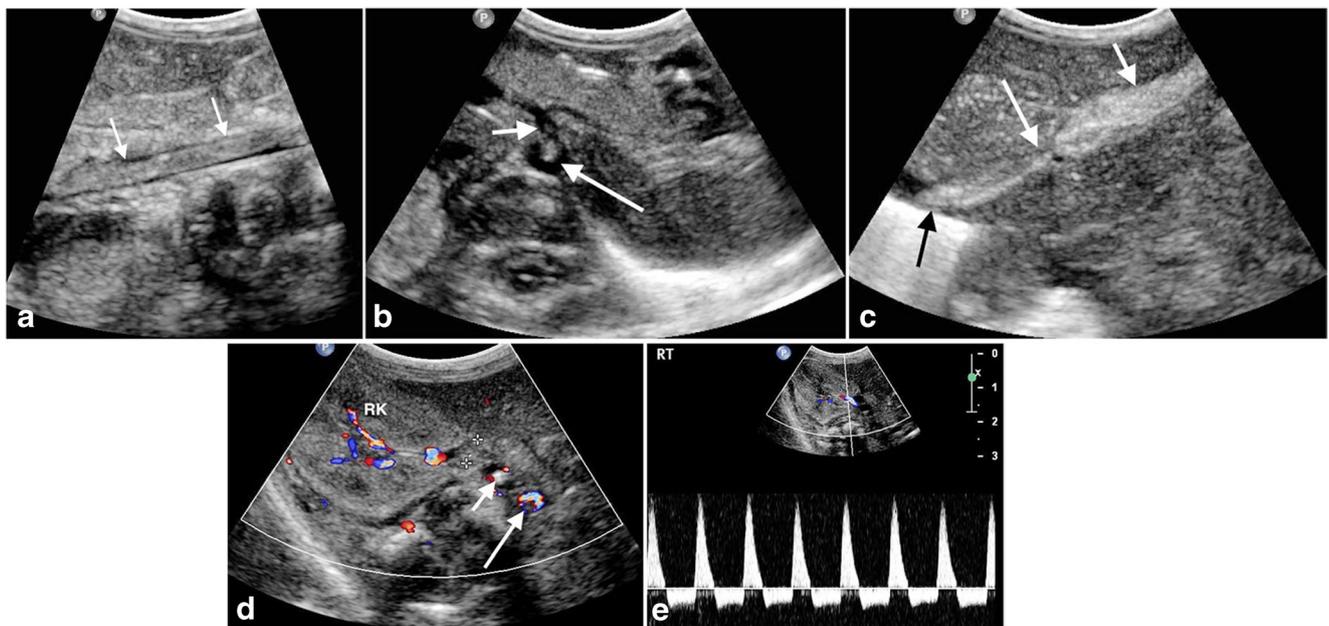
Aortic, inferior vena cava, portal vein and renal vein thrombosis in a 16 day-old girl born at 29-week-gestation. The baby had an umbilical venous catheter and umbilical arterial catheter prior to this ultrasound. a Longitudinal ultrasound image of the midline upper abdomen shows a large echogenic aortic thrombus (*arrows*). Acute thrombus can appear hypoechoic and completely occlude the vessel, which usually appears expanded. With time the clot becomes more echogenic and might retract, and the vessel re-canalises. b Transverse ultrasound image of the upper abdomen shows extension of the thrombus from the aorta (*long arrow*) into the coeliac axis (*short arrow*). c Longitudinal
